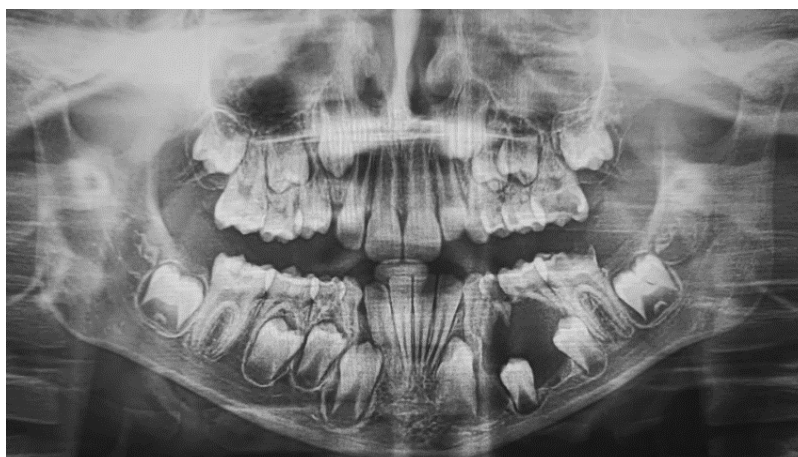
Radiological examination : Panoramic radiography showing the lesions' limits.
